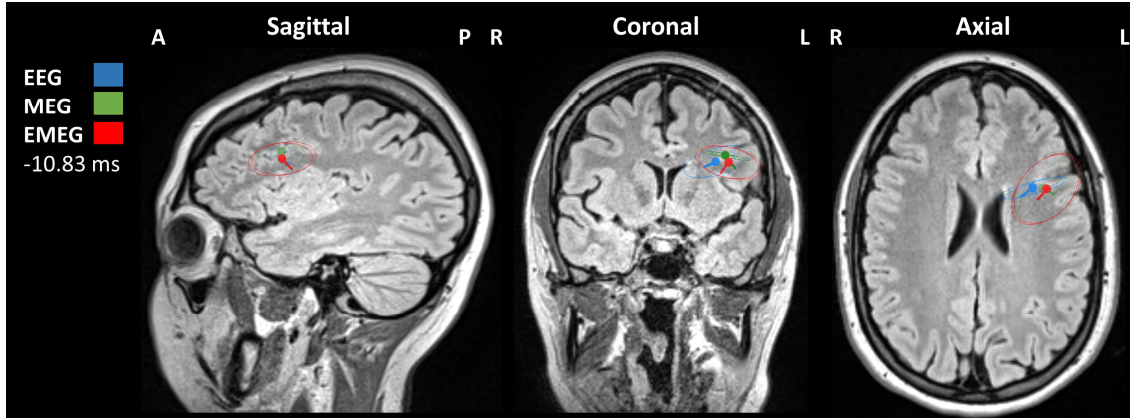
Spike cluster centroids and spread ellipsoids plotted on the T2w-FLAIR MRI of the patient at the onset of the spike peak (-10.83 ms). The results are presented in blue for EEG, in green for MEG, and in red for EMEG. The letters, A, P, L and R denote 'anterior', 'posterior', 'left' and 'right' respectively.
